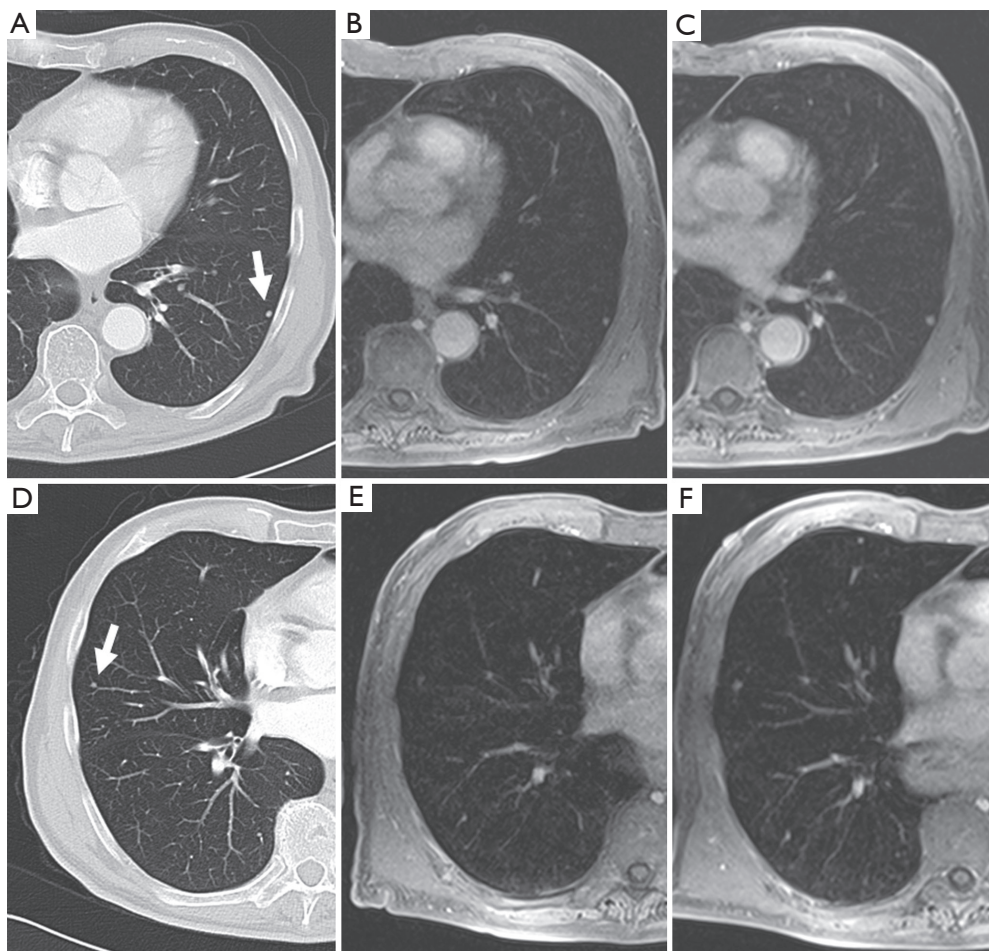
An example demonstrates MRI for the detection of small lung nodules: (A,D) small pulmonary metastases of a malignant melanoma in a 62-year-old patient (5 mm slices of a standard helical CT scan); (B,E) MRI of the corresponding positions at the same time; (C,E) the follow-up MRI after 3 months [the contrast enhanced transverse 3D-GRE (VIBE) images; TR/TE 3.15/1.38 ms, flip angle 8°, FOV 350 mm × 400 mm, slice thickness 4 mm]. The clearly visible 3 mm nodule in the left lower lobe [(A) and (B); marked with an arrow on (A)] grew to a diameter of 5 mm within 3 months (C). Another 3 mm nodule in the lateral right middle lobe [marked with an arrow on (D)] is hardly visible on the corresponding MRI due to cardiac pulsation, but becomes clearer in the follow up study after growing to 4-5 mm (F) [Reproduced with permission from reference (23)].
